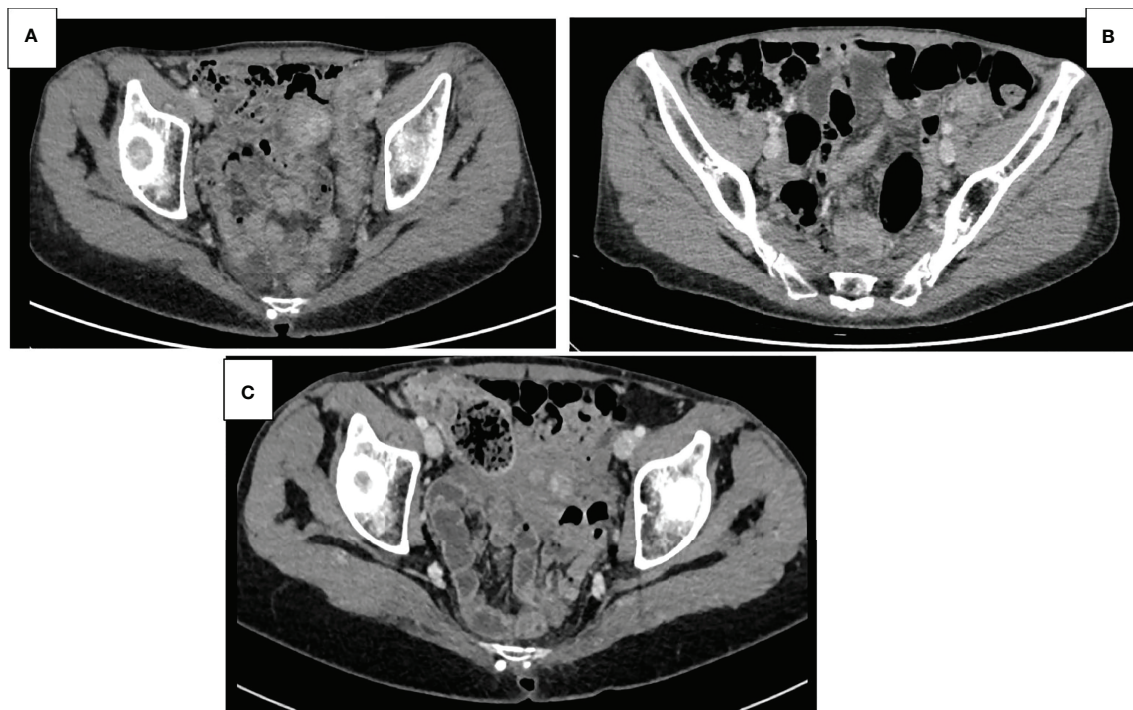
Basal abdominal CT scans at the onset symptoms of pan-colitis with diffuse thickening of the colon walls (A). Improvement of pan-colitis after 8 months of infliximab treatment and 9 months of Pembrolizumab discontinuation (B). Persistent mild colitis after 24 months of Pembrolizumab discontinuation (C).
